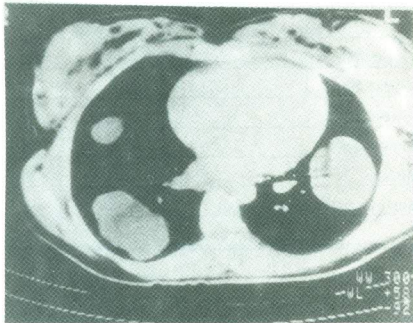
Chest CT scan of the same patient with bilateral multiple pulmonary hydatid cysts.
